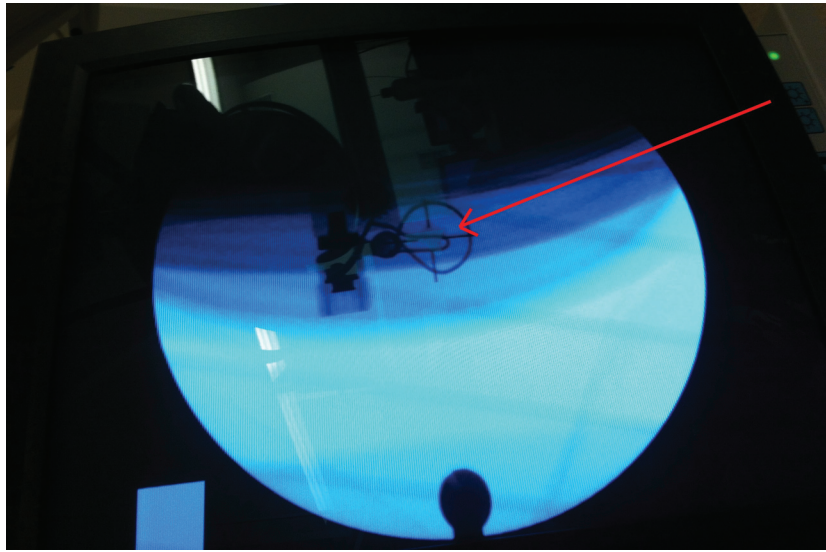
The stone and mounting mechanism seen on the x-ray monitor. The model stone is in the middle of the crosshairs, marked by the red arrow.
